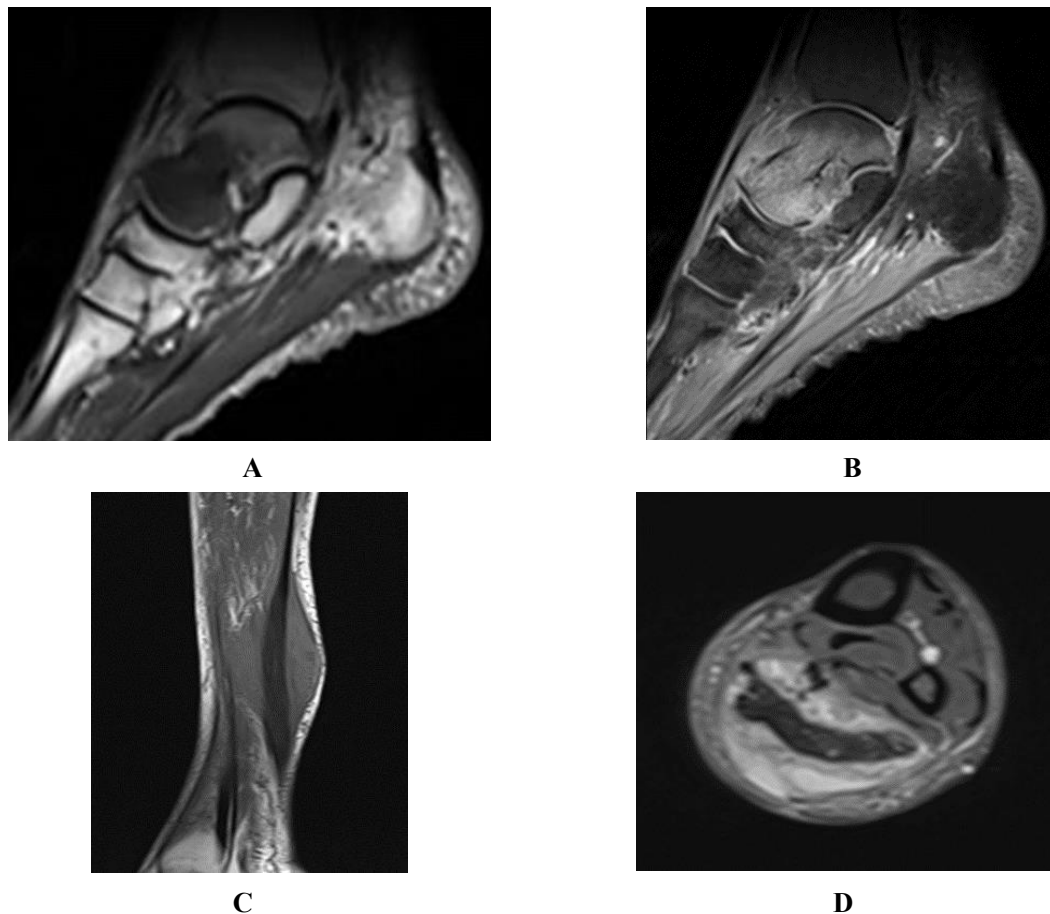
Ankle magnetic resonance imaging (A-D) showed a defect in the talus
